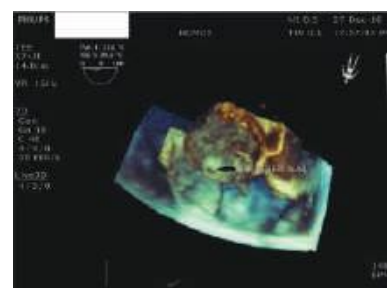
3D-Transesophageal echocardiogram view from the aortic side revealing a small defect in the aneurysmal sac.
